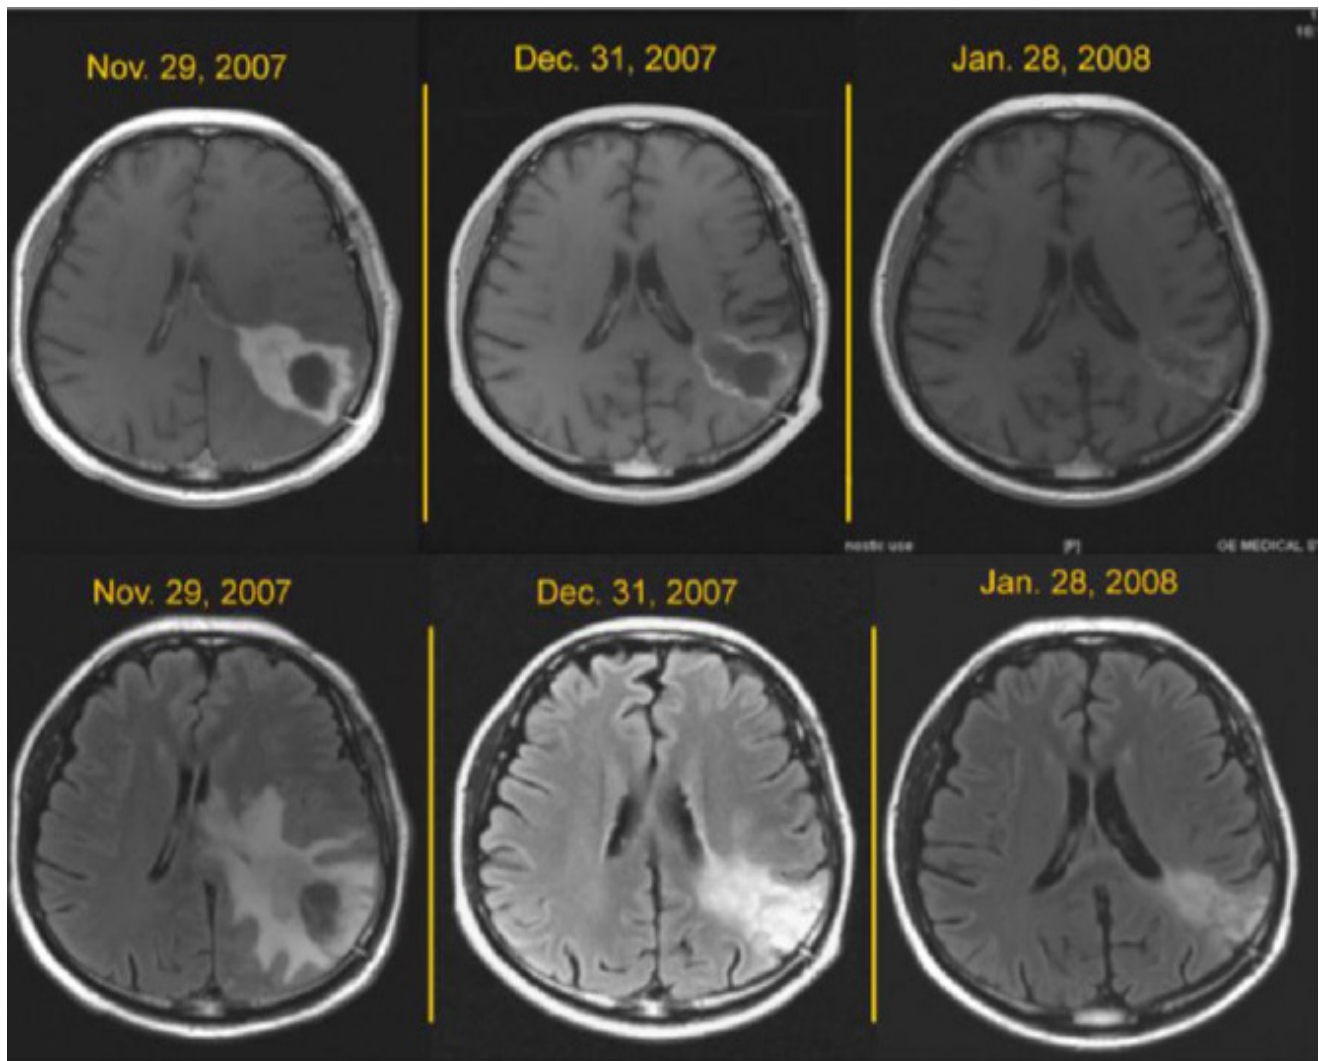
Post contrast Axial T1 images (upper) and FLAIR images (lower) before and after treatment with bevacizumab and CPT11. Note the progressive regression of size, contrast enhancement, and signal's abnormal intensity with consecutive treatments
